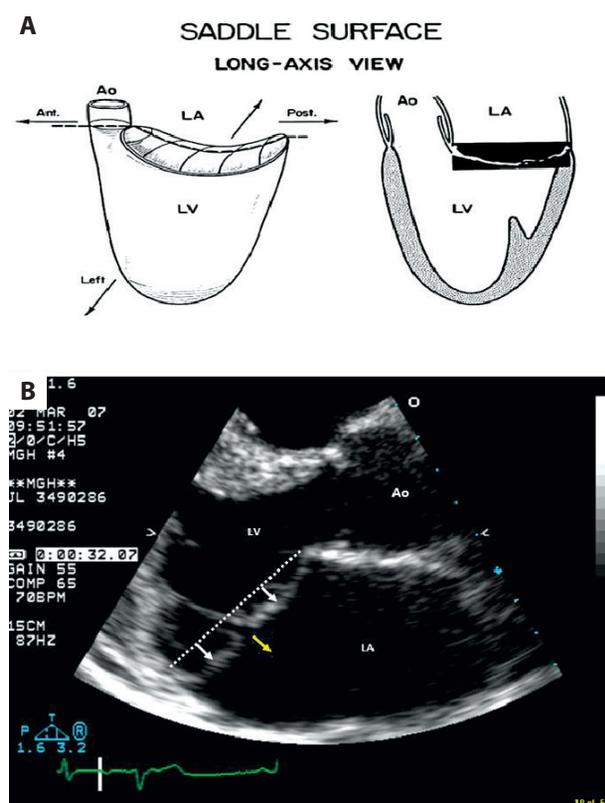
A. Mitral valve prolapse (MVP) is defined by the abnormal position of the mitral leaflets to their surrounding structures. Cardiac ultrasound is well suited for MVP phenotyping. B. Parasternal long-axis view of a human heart with MVP. The leaflets are above the annular line (the dotted line) during systole (the white arrows). The gap between the leaflets generates the potential for regurgitation (the yellow arrow). Adapted from [6]
